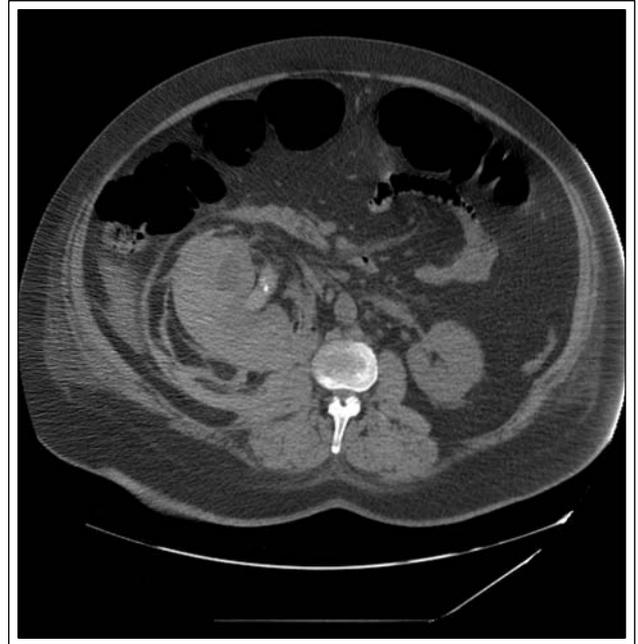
CT Revealing expansion of right perirenal hematoma.
